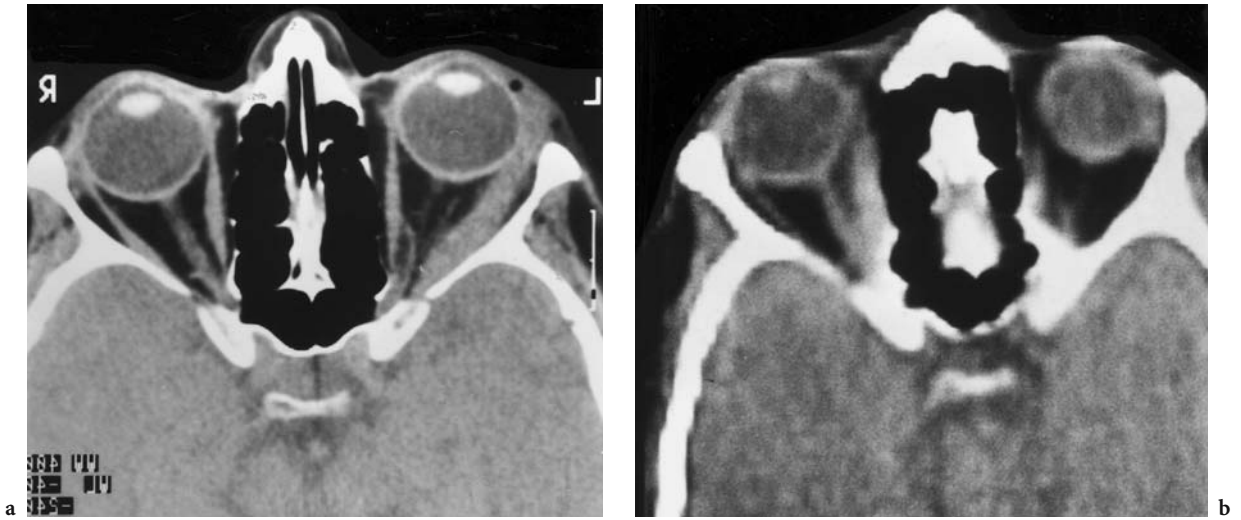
A 56-year-old woman with painful proptosis of the left eye; the patient reported occurrence of the same symptoms on the contralateral side several years previously. Diagnosis: myositis of the left lateral rectus muscle. Axial CT: a thickening of the left lateral rectus muscle, including the tendon insertion. b CT done some years before, demonstrating inflammatory involvement of the contralateral medial rectus muscle. (With permission of MÜLLER-FORELL and LIEB 1995b)
